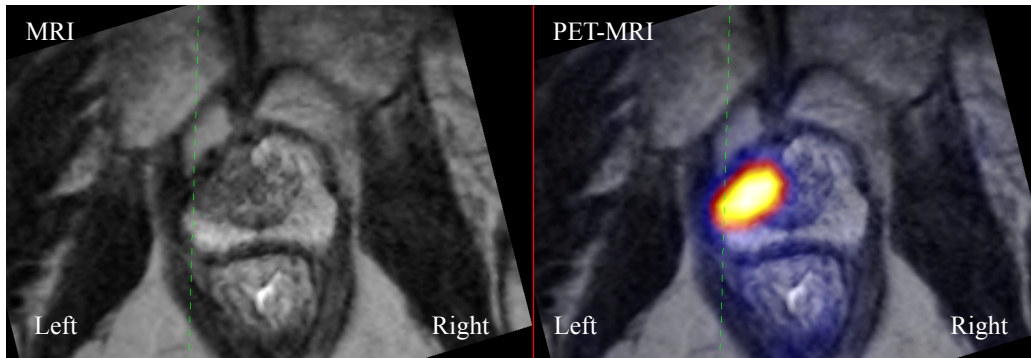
The presented prostate biopsy guidance system provides the urologist with MRI and PET/MRI views corresponding to the current position of the TRUS transducer. The PET/MRI view shows a hotspot in a suspicious region in left apical prostate zone where the target biopsies were taken. Note that because the urologist turns the transducer by 180° to take biopsies from the patient's left side (thus flipping the TRUS image), also the MRI and PET/MRI slices become flipped in our visualization. *Reprint from [256] with permission of Springer.*
